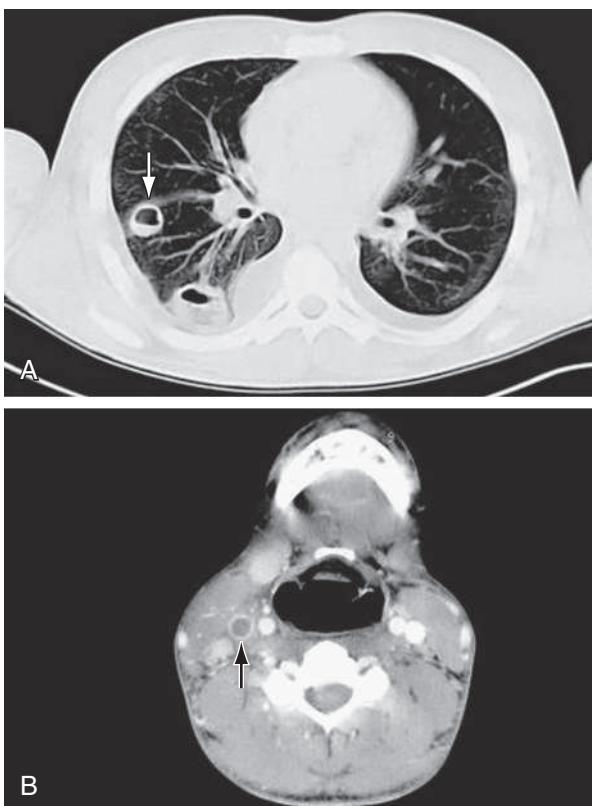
CT of Lemierre disease. A, CT demonstrating the nodular appearance of pulmonary infiltrates (arrow). B, CT of the neck demonstrating thrombosis of the right internal jugular vein (arrow). (From Plymeyer MR, Zoccola DC, Tallarita G. An 18 year old man presenting with sepsis following a recent pharyngeal infection. *Arch Pathol Lab Med*. 2004;128:813. Copyright 2004. College of American Pathologists.)
